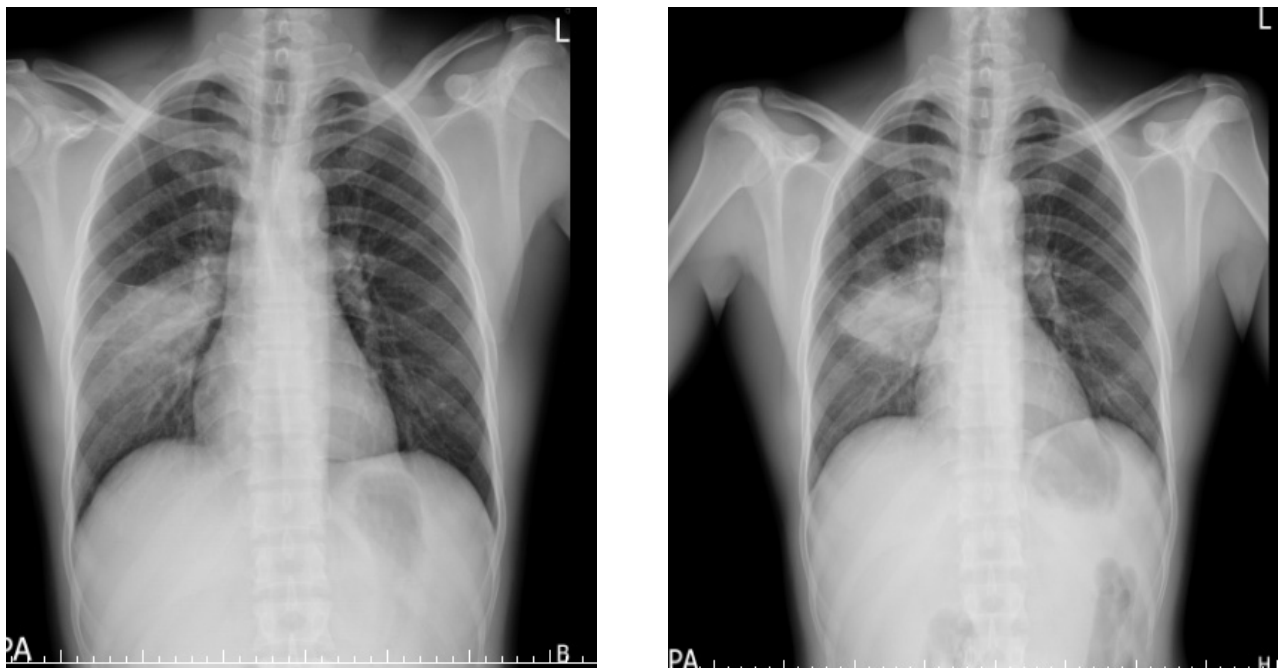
(A) The chest X-ray 2 weeks before referral presents right lower lobe opacity; (B) The chest X-ray on referral day presents stationary right lower lobe lesion compared with previous film.
